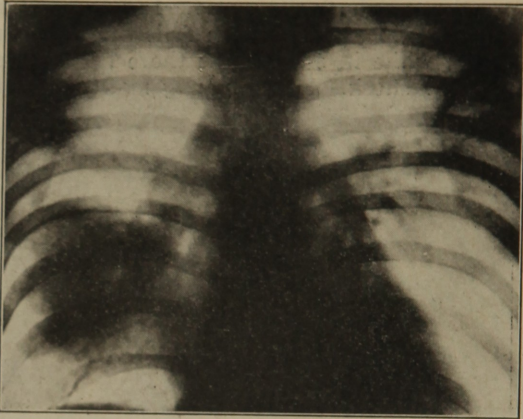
Radiograph of the same patient as pictured in Fig. 7, after seven lung washings. The density of the shadow has slightly decreased. The abscess cavity could not be entered by the special long bronchoscope, for it was around a corner.
